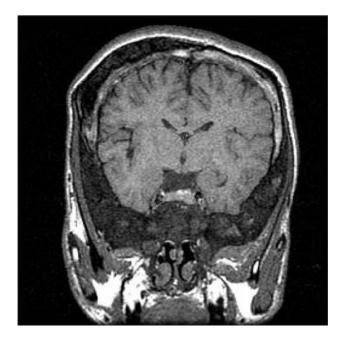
Frontal MRI showing normal size of pituitary with nonuniform signal, and irregular thickening of cranial bones
